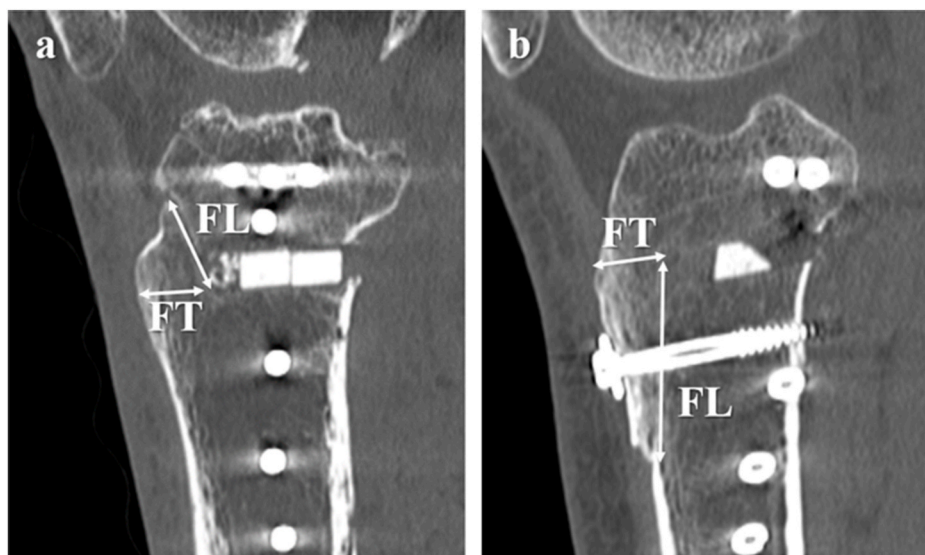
Measurement of flange thickness (FT) and flange length (FL) on sagittal CT slice in (a) high tibial osteotomy (HTO) and (b) distal tuberosity osteotomy (DTO). The slices were at the centre of the flange. FT was measured at the base of the flange. FL was measured as the distance between the distal osteotomy level and the proximal end of the flange in HTO and the distance between the proximal osteotomy level and the distal end of the flange in DTO.
